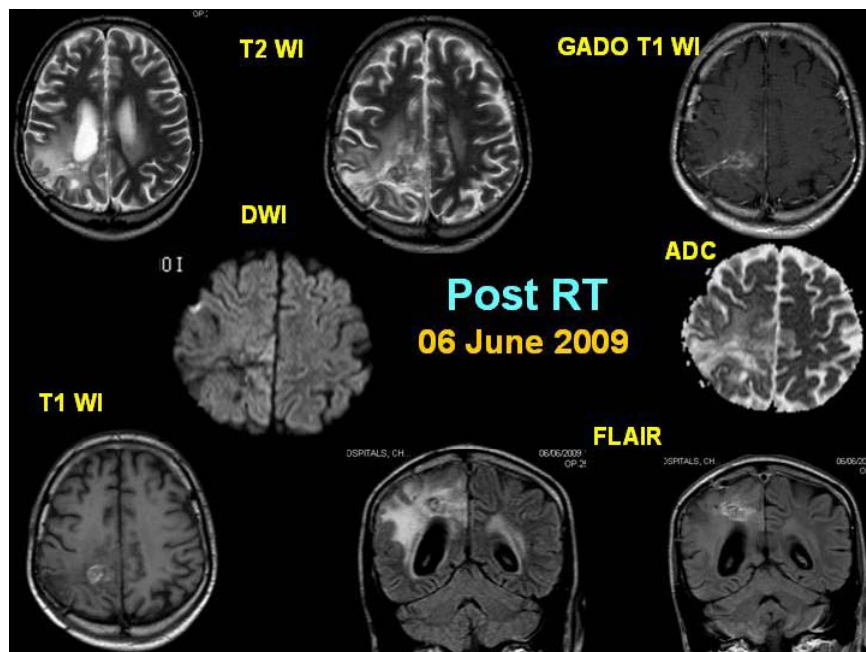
Post operative and post radiotherapy follow up of CNS Neuroblastoma- MRI after 15 months shows patchy enhancing areas in the right parietal lobe associated with area of gliosis suggesting doubtful recurrence
